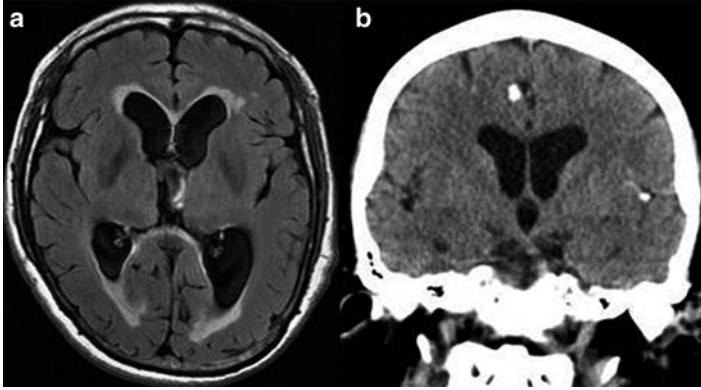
Imaging findings in patients with neurocysticercosis. (a) MRI showing hydrocephalus with transependymal edema. (b) CT showing calcified cysticerci associated with ventriculomegalia
